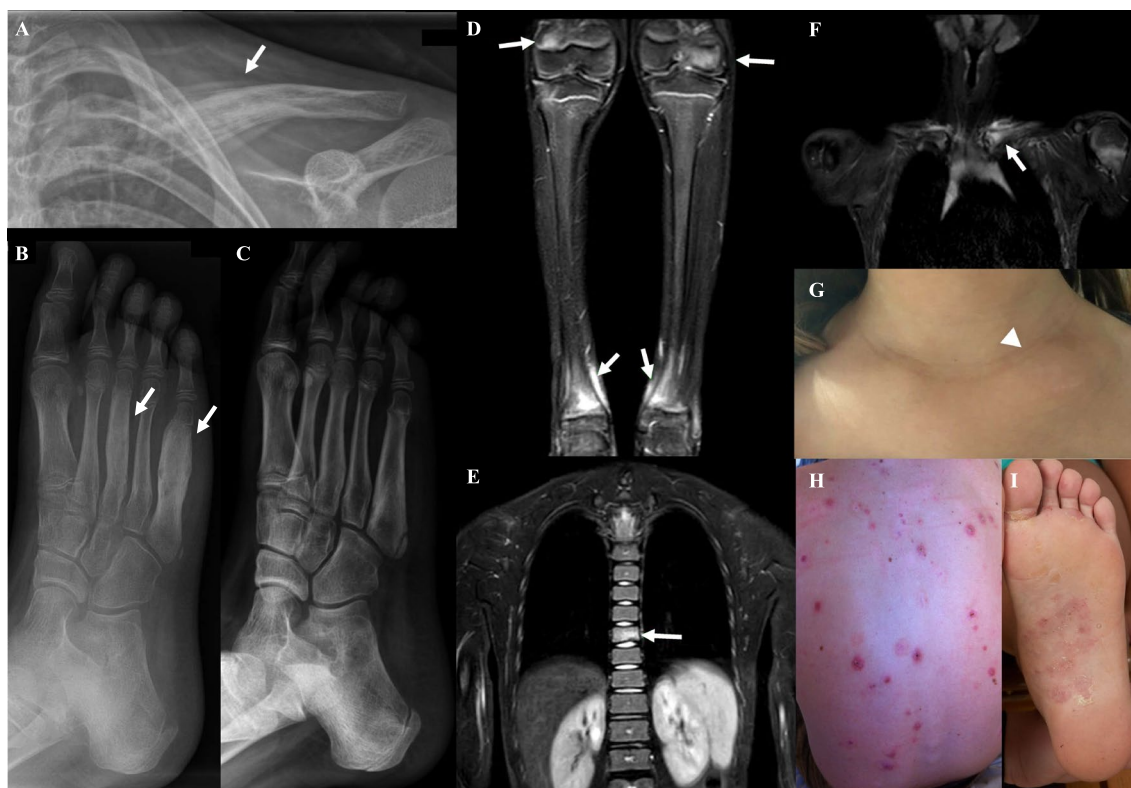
Typical aspect of CNO/CRMO Radiographs findings in CNO/CRMO (A–C). Typical CNO/CRMO lesion on the medial clavicle portion, with osteolysis and periosteal reaction (A, arrow). CNO/CRMO lesions of the 3rd and 5th metatarsal bones showing osteolysis and hyperostosis (B, arrows). Favorable evolution of the lesions after 1.5 years of treatment (C). MRI findings in CNO/CRMO (D–F): hyper intense signal (STIR-TSE sequence) in lower limbs epiphysis/
